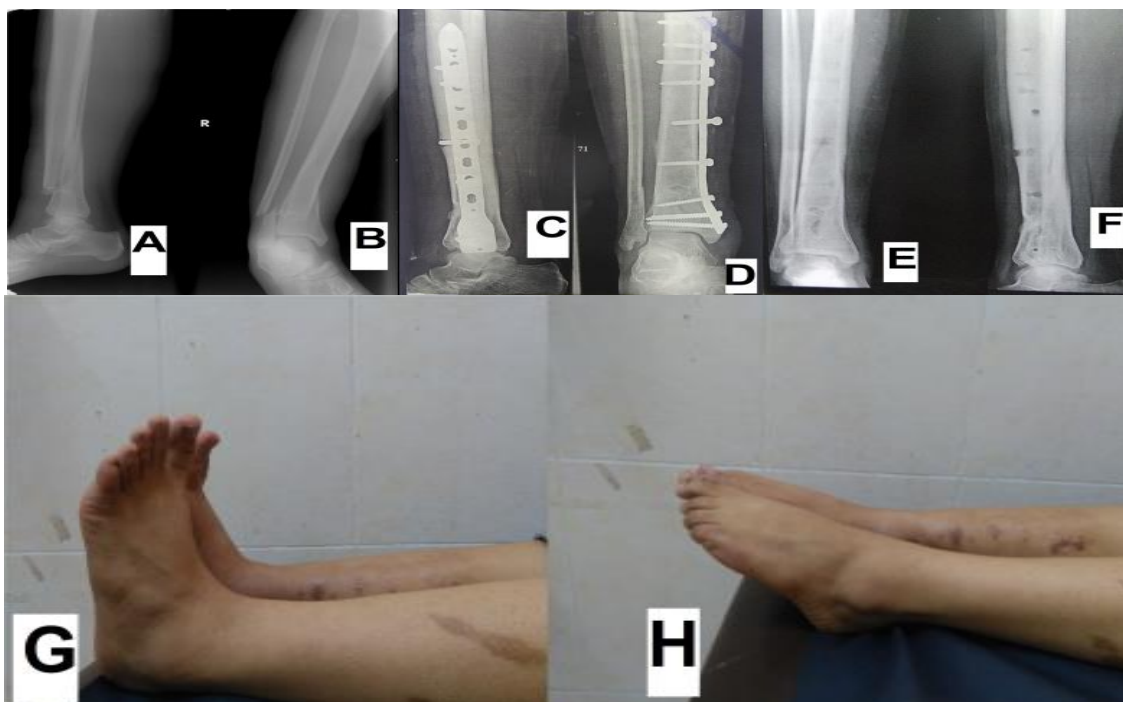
Pre-operative x-ray lateral(A) and anteroposterior(B) views; (5) months follow up x-ray lateral(C) and anteroposterior(D) views showing full union of the fracture; (6) months x-ray anteroposterior(E) and lateral(F) views after infected plate removal, full ROM(D-F 20°(G) & P-F 40°(H))6months.
